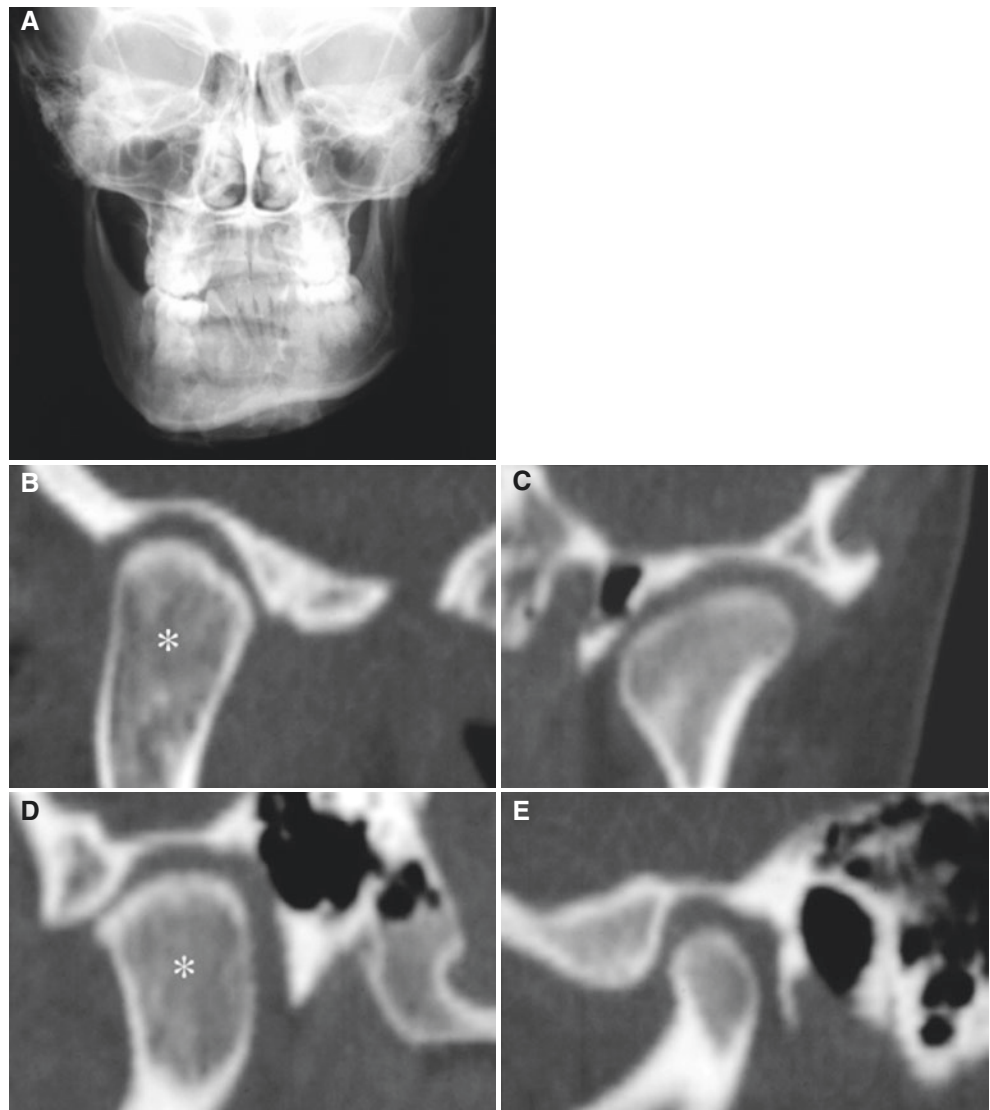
Condylar hyperplasia and facial asymmetry; 23-year-old female. (A) Facial (*front*) view shows jaw asymmetry due to unilateral mandibular overgrowth (*right side*). (B) Oblique coronal and (D) oblique sagittal CT images show mandibular condyle (*asterisk*) with abnormal shape and size, enlarged but not in mediolateral dimension, and widened fossa in anteroposterior dimension. (C) Oblique coronal and (E) oblique sagittal CT images show normal contralateral joint. Panoramic view of this patient is shown in Fig. 9.6
